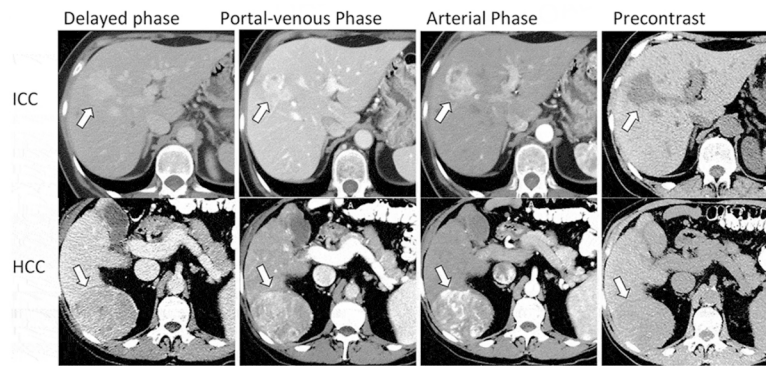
Hepatocellular carcinoma (lower panel) versus intrahepatic cholangiocarcinoma (upper panel) on computed tomography imaging^[17]. The figure was reprinted from reference 17 with permission.
